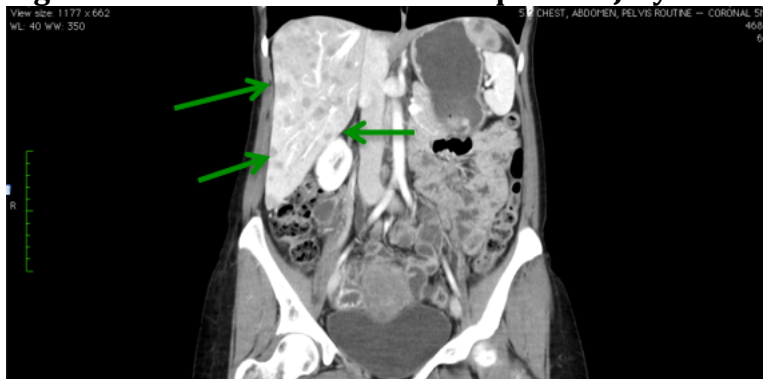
CT scan of abdomen & pelvis - July 2013
